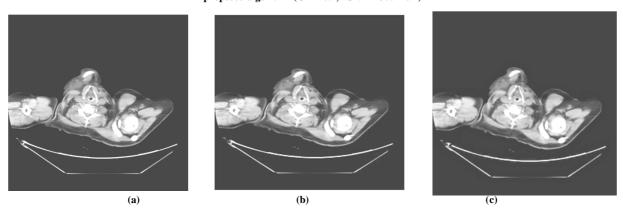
(a) Original CT image (b) Reconstructed image using SPIHT (CR = 8.6, PSNR = 36.60 dB) (c) Reconstructed image using the proposed algorithm (CR = 8.9, PSNR = 36.62 dB)
